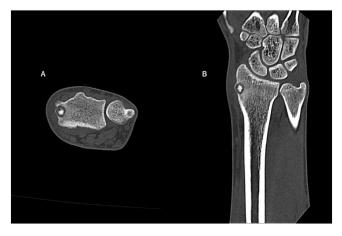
Computed tomography of the right wrist with a nidus and central mineralization.
